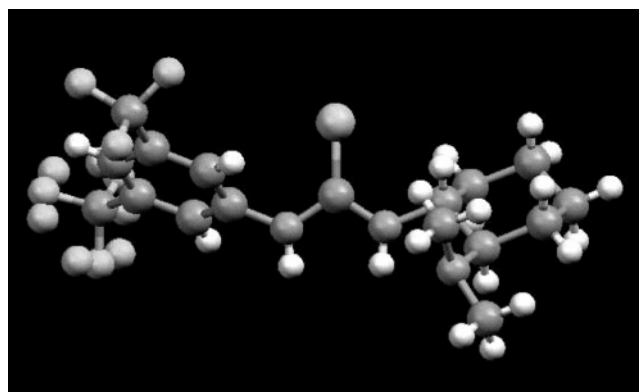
X-ray analysis of *rac*-1e.
